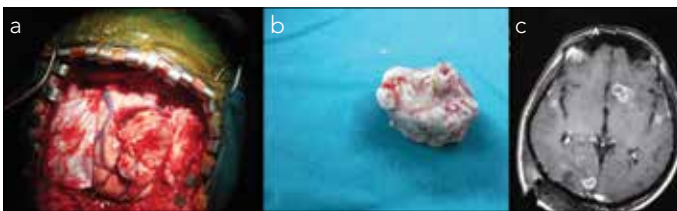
a-c. One of the multiple lesions in the brain was excised (a, b); immediate post-operative brain MRI depicts en bloc resection of the lesion that was present in the right occipital lobe (c)
